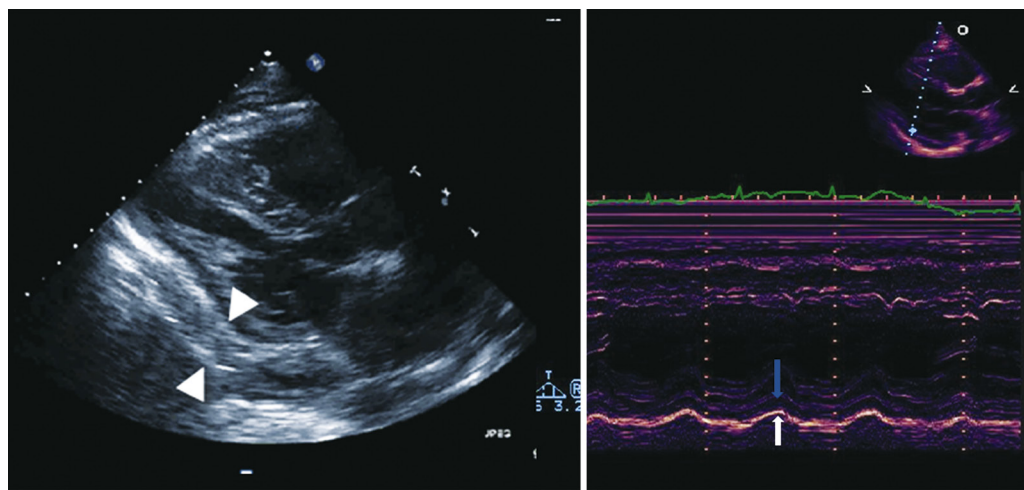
Left, Parasternal long-axis view demonstrating thickened pericardium (between arrows). Right, M-mode echocardiogram. The bright posterior echo (*white arrow*) representing the parietal pericardium moves in parallel with the visceral pericardial/epicardial echoes (*blue arrow*), a finding indicative of adhesion between the two layers. If the pericardial space were expanded by free fluid (pericardial effusion), the parietal pericardial echo would be relatively stationary (compare with the M-mode inset of Fig. 16.60).
